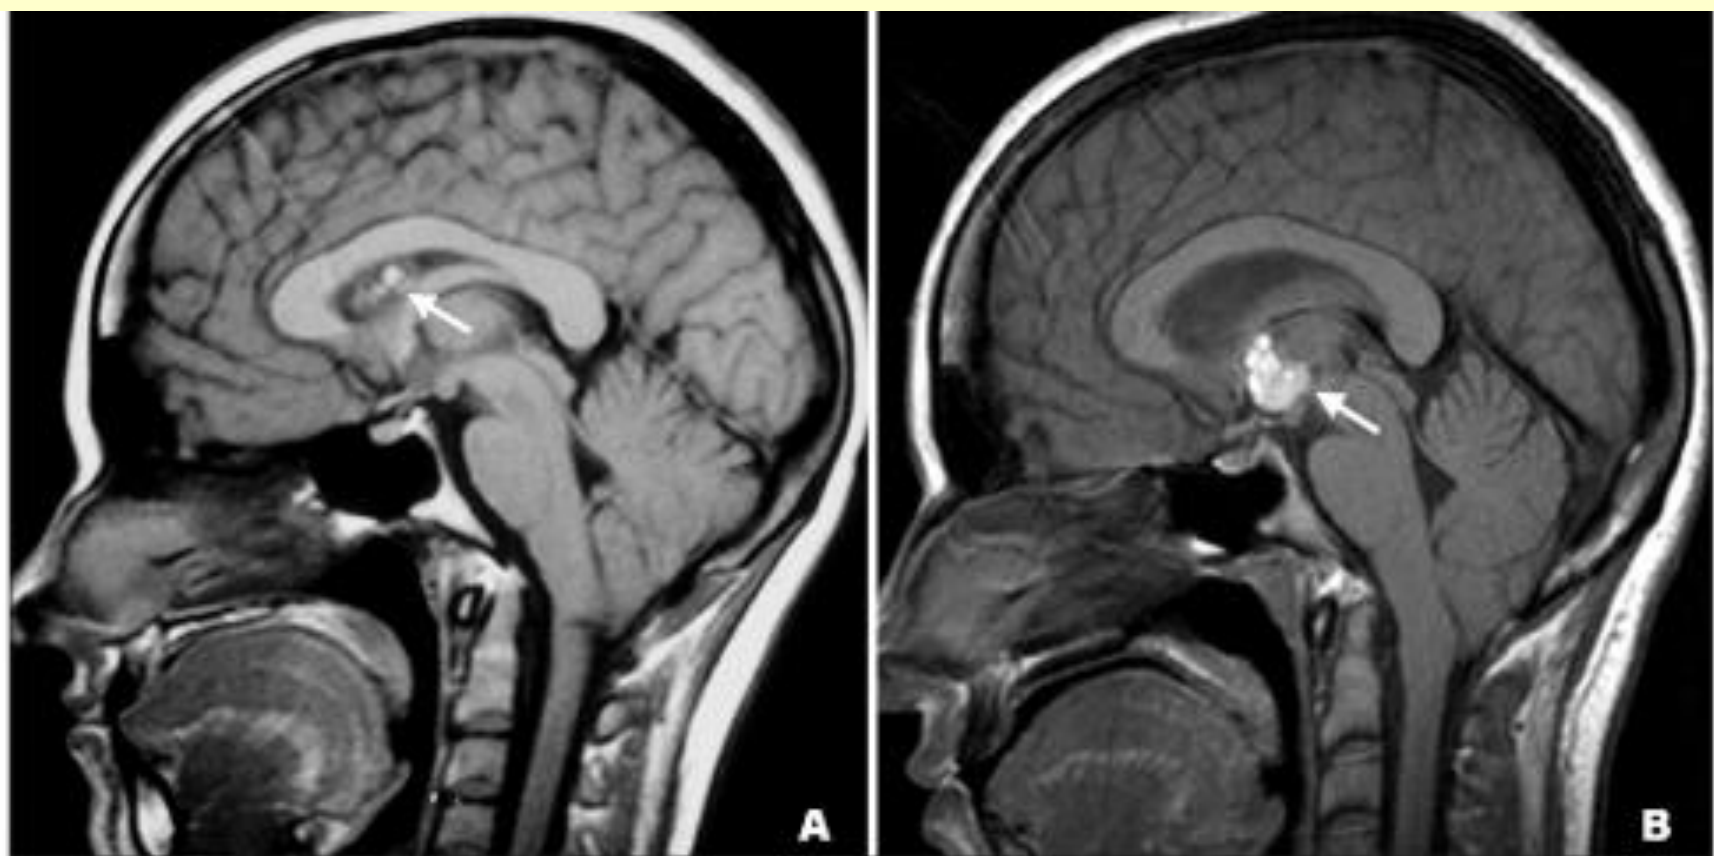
Sagittal T1-weighted MR images demonstrate a multiloculated lesion in the lateral ventricle (arrow) in the first exam (A), and the lesion migrating to the third ventricle (arrow) on the follow-up (B).
